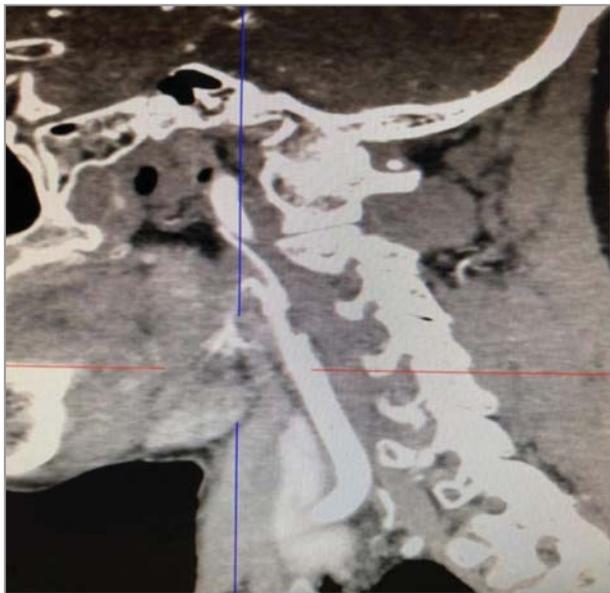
Sagittal plane CT angiogram showing narrowing/stenosis of the internal carotid artery.
